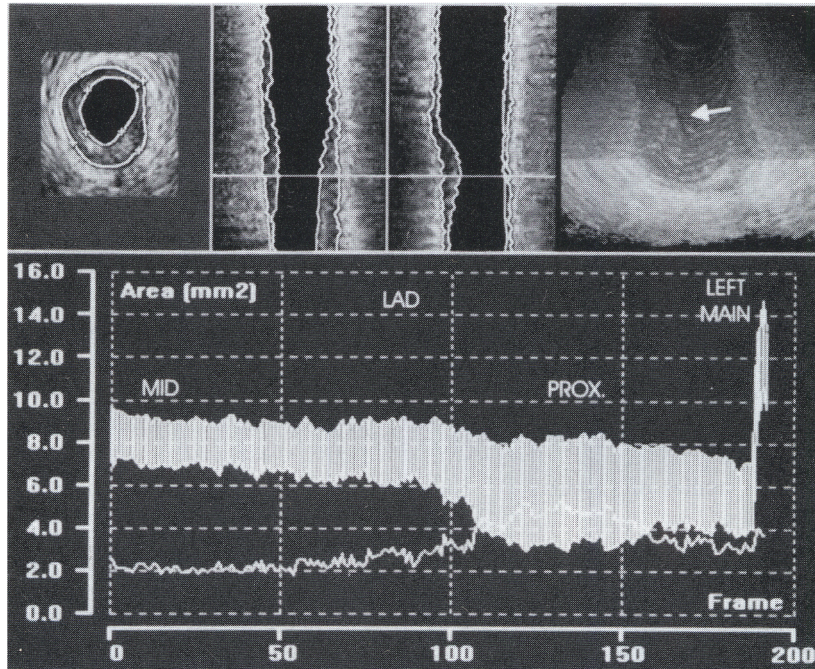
Primary lesion in the proximal segment of the left anterior descending coronary artery (LAD), assessed by a new system for quantitative analysis of three-dimensional intracoronary ultrasound images. The cross-sectional ultrasound images, representing a segment of round 10 mm length, were reconstructed in two perpendicular longitudinal sections (mid panels). A computerized contour detection was performed providing a three-dimensional view (right upper panel; arrowhead indicates target stenosis) and area measurements ( $\text{mm}^2$ ) of the lumen, plaque, and total vessel on 200 consecutive ultrasound frames (lower panel). The values of the plaque area are shown as a white field between two lines, representing the absolute values of the total vessel and lumen areas. The absolute value of the plaque area can be derived from this white field, but is also displayed as a single white line. The area stenosis at the site of the mid segment of the LAD was round 20%. According to the mechanism described by Glagov, an enlargement of the total vessel area, partly compensating the plaque burden, may be expected at the site of a relatively focal plaque. In the measurement display of this case, however, a paradoxical reduction of the total vessel area from the distal reference in the early mid LAD (MID) to the target stenosis in the proximal segment (PROX) was observed. Plaque volume of the entire arterial segment was  $32 \text{ mm}^3$ .
